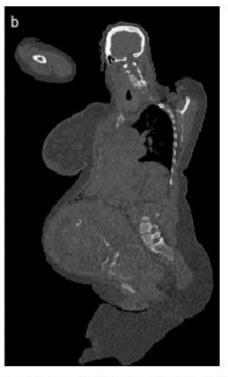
¹⁸F-FDG PET/CT image including both the mother and the foetus with (a) a Maximum Intensity Projection (MIP) ¹⁸F-FDG PET image and (b) a slice of the ultra-low-dose CT scan
